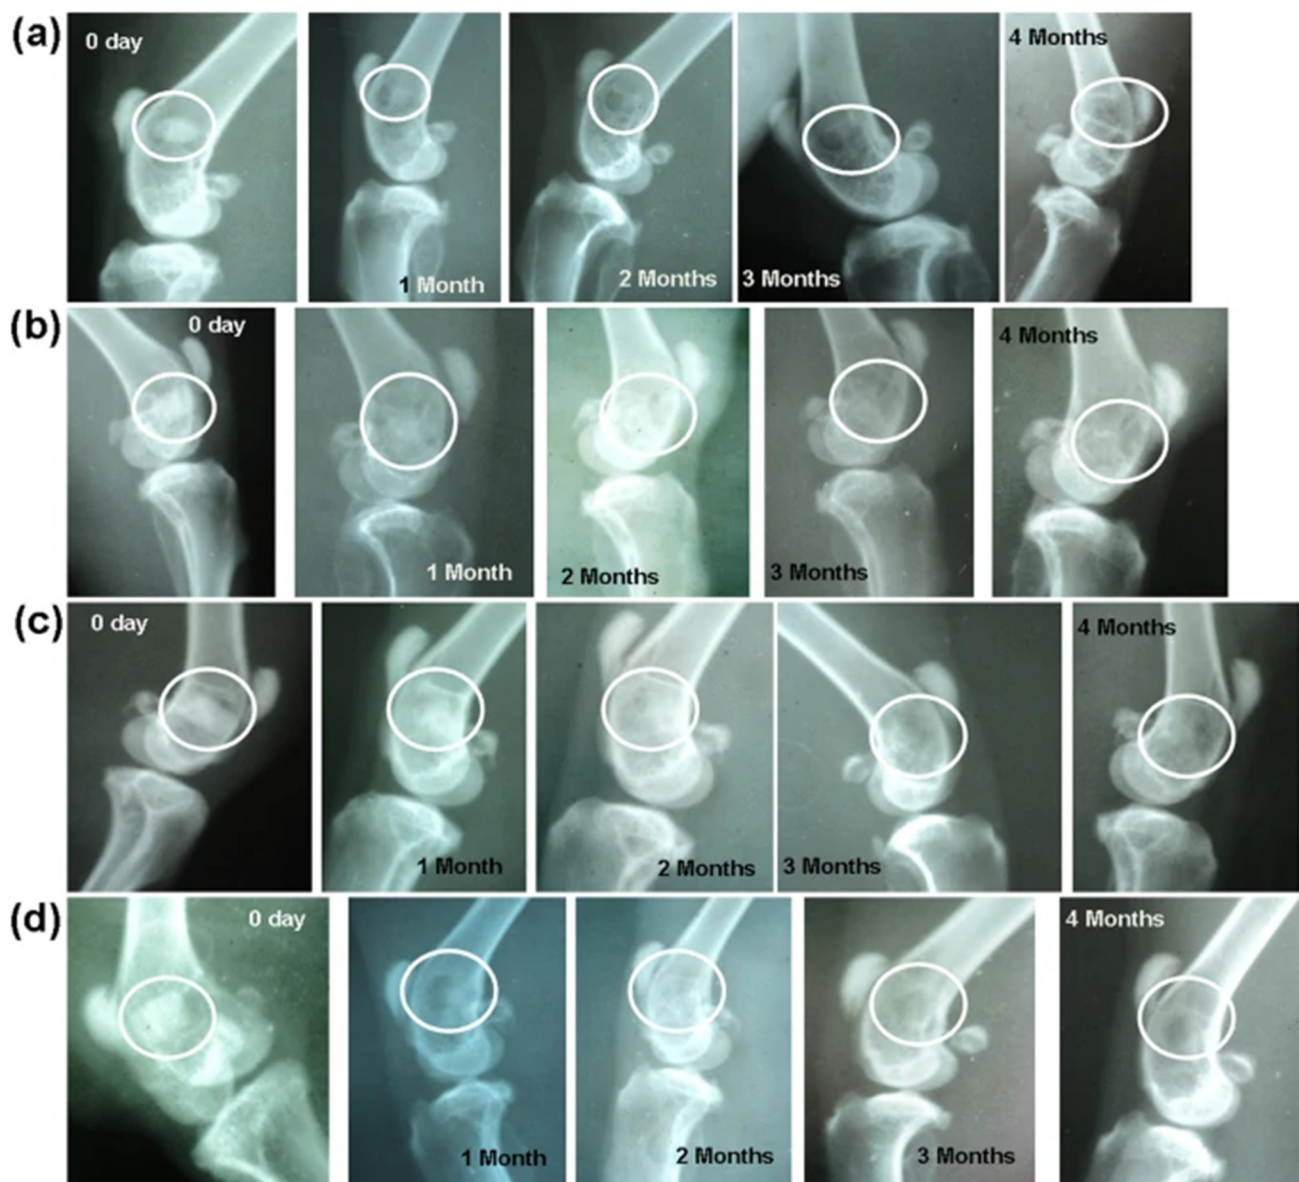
Radiographs taken after implantation and after 1, 2, 3 and 4 months post-operation. BG compositions implanted are (a) BG, (b) L-BG, (c) S-BG, and (d) LS-BG. From Khan *et al.*³²³ with permission from Springer Nature, 2016.
